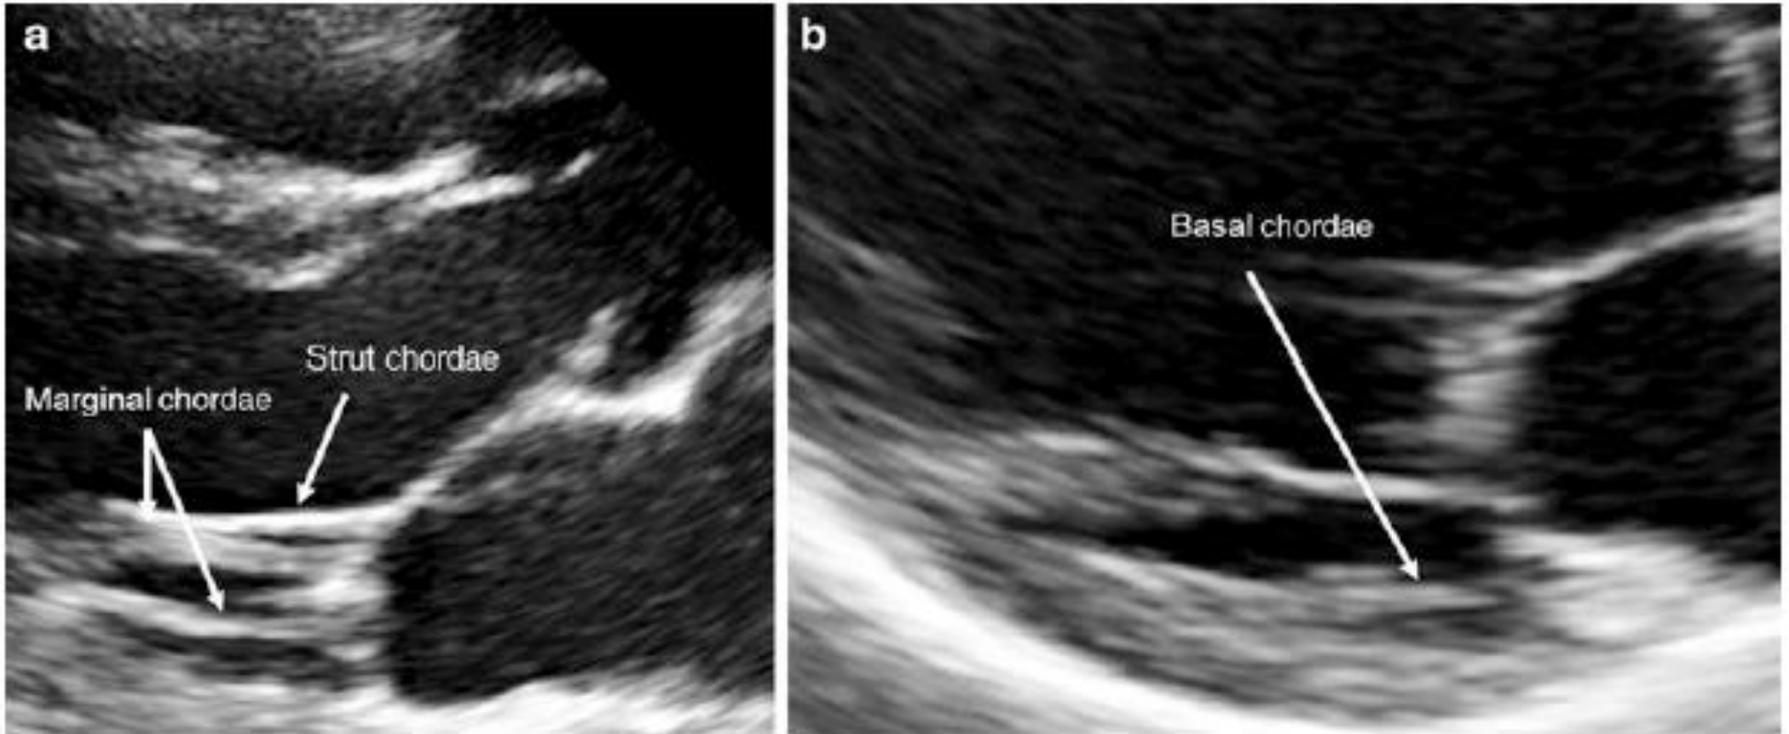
Two-dimensional parasternal long-axis views where all three types of chordae (*strut* and *marginal* in panel a, *basal* in panel b) can be distinguished
